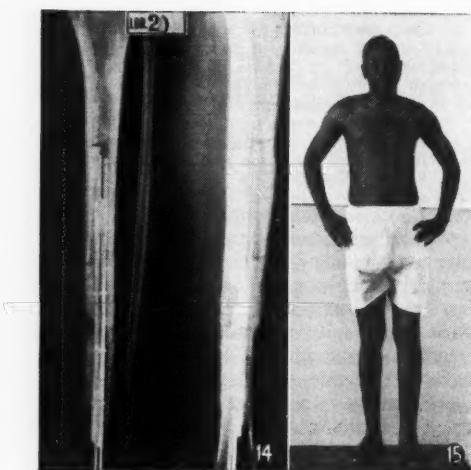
Case No. 1. Post-operative X-ray.
